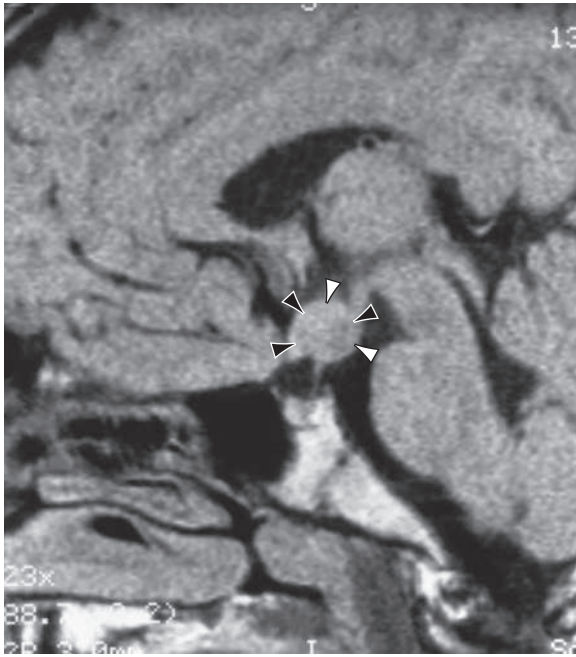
MRI of a central nervous system lesion in a child with central precocious puberty. A 6-yr-old female was referred for stage IV breast development and growth acceleration. Serum luteinizing hormone and estradiol concentrations were in the adult range. The mid-sagittal T1-weighted image shows an isointense hypothalamic mass (arrowheads), typical of a hamartoma. (From Sharafuddin M, Luisiri A, Garibaldi LR, et al. MR imaging diagnosis of central precocious puberty: importance of changes in the shape and size of the pituitary gland. *Am J Roentgenol*. 1994;162:1167–1173.)
